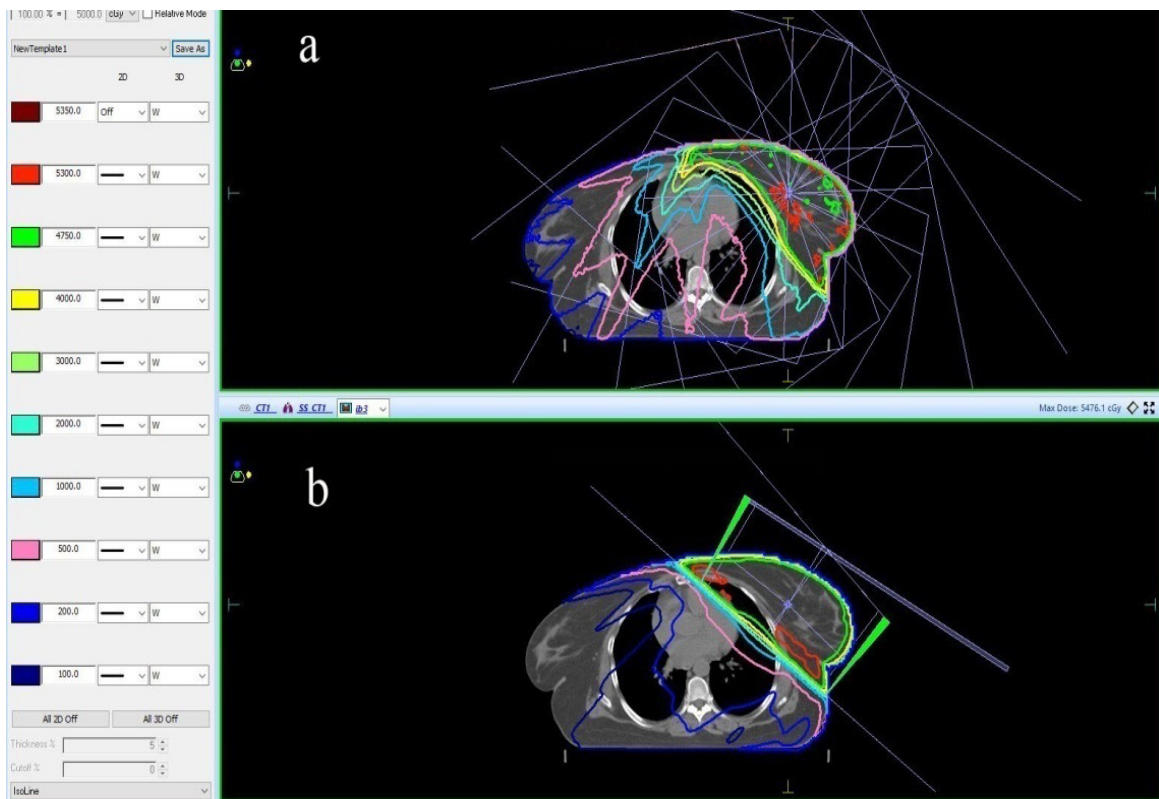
The beams arrangements and isodoses distributions on transverse CT planning. (a) for IMRT plan. (b) for 3DCRT plan.
